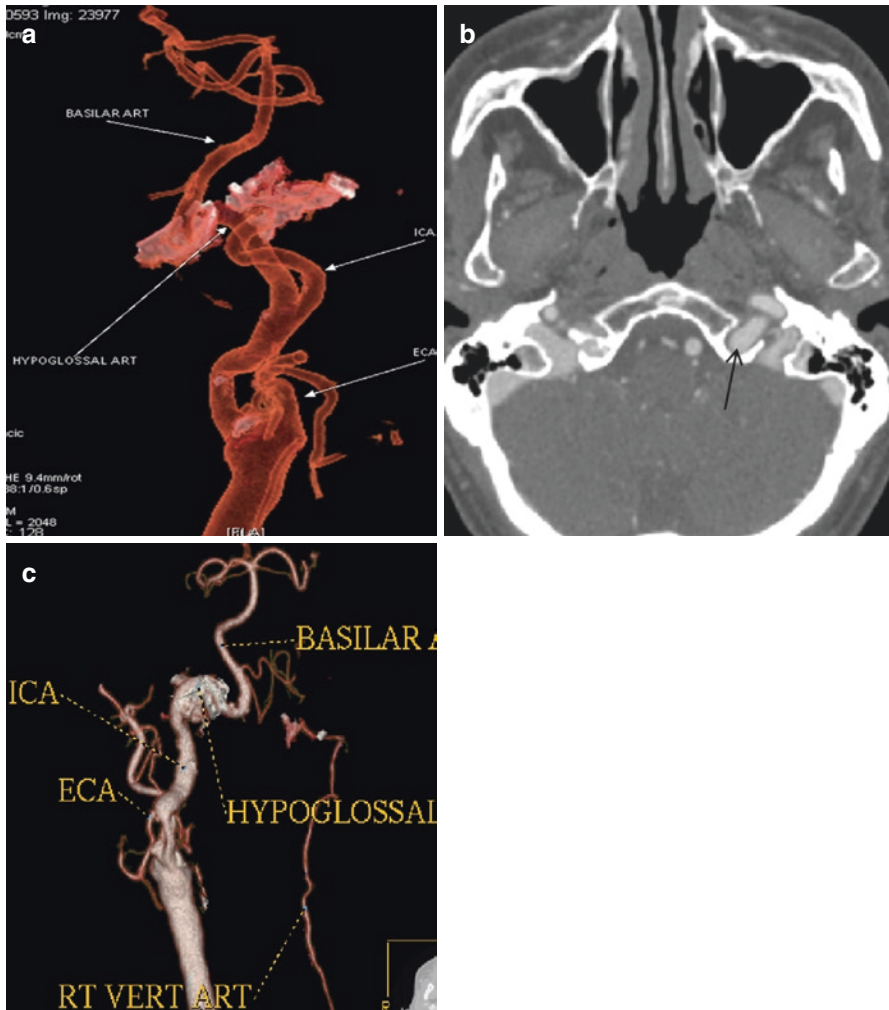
(a) CTA (VRT 3D reconstructions) shows a vessel connecting the ICA with the basilar artery (annotations) (Reproduced from Zampakis et al. [6]). (b) Axial CT image at the level of hypoglossal canal shows an enlarged vessel piercing the skull base on the left, through the hypoglossal canal, which has been also enlarged (*black arrow*) (Reproduced from Zampakis et al. [6]). (c) CTA (VRT 3D reconstructions) reveals absent proximal vertebral artery and hypoplastic contralateral vertebral artery (annotations) (Reproduced from Zampakis et al. [6])
